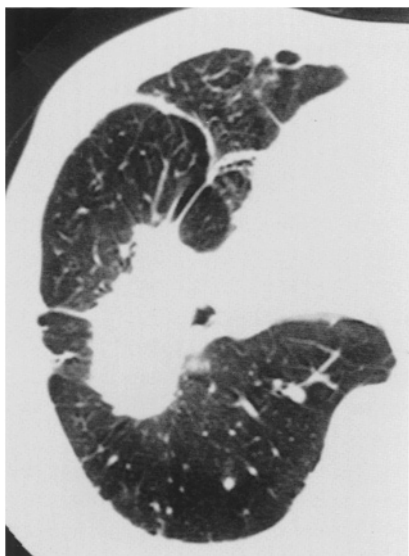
HRCT scan of complicated silicosis. Progressive massive fibrosis (PMF) is seen in posterior segments of upper and lower lobes. Compensatory emphysema is seen around the PMF
